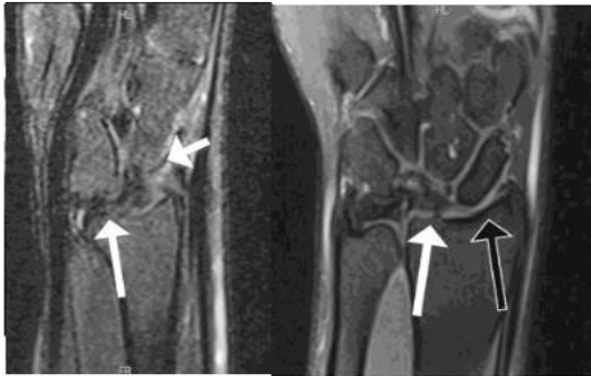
A) Dorsal inclination of the lunate with hypointensity data on T1, compatible with Lichtman grade 1 avascular necrosis; B) MRI complete rupture of the dorsal component of the scapholunate ligament (white arrow) widening of the scapholunate interval preservation of the radiolunar and radioscapoid articular cartilage (black arrow).
